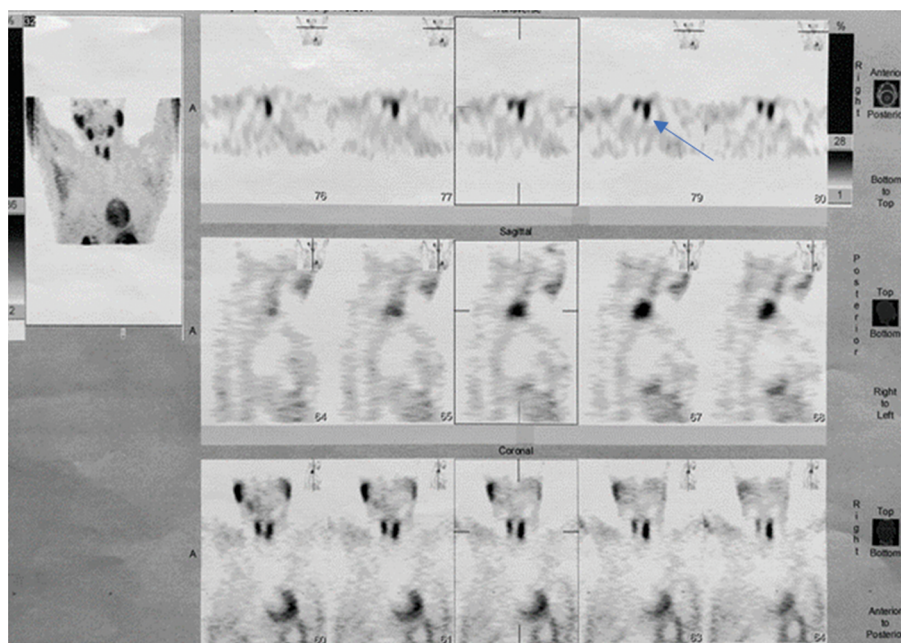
The early SPECT images show an area of increased accumulation located dorsally of the caudal part of the left thyroid lobe.
